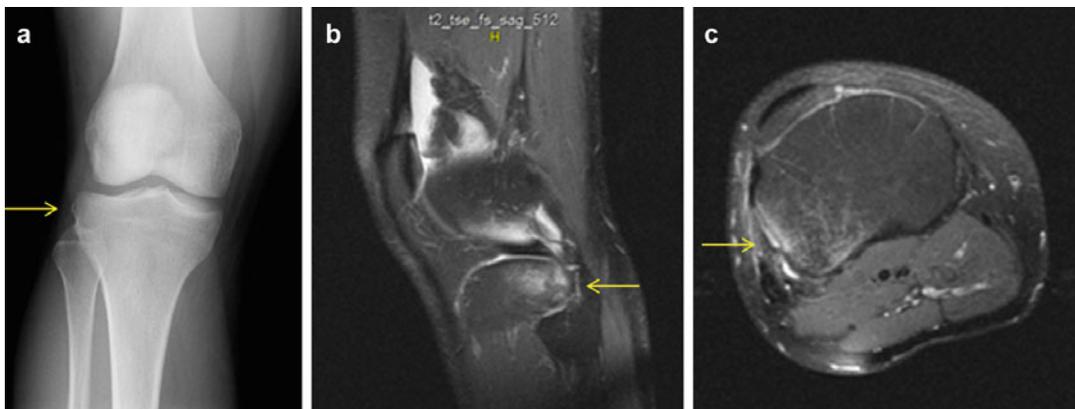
Example of Segond fracture is difficult to identify on radiographs (yellow arrows) (a) but better clarified on MRI T2 sagittal view (b) and axial view (c)
